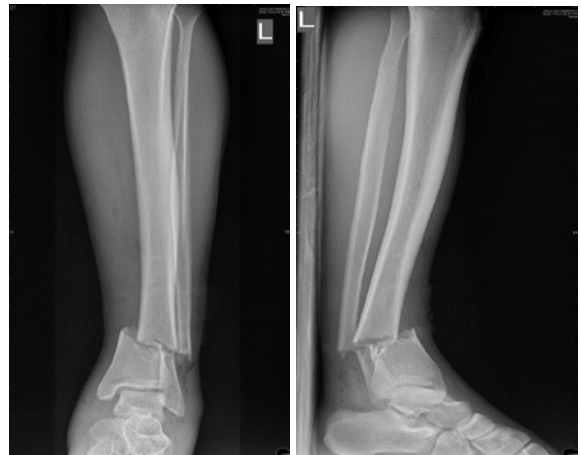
Preoperative Radiograph of Extra articular Distal Tibia Fracture In Anteroposterior And Lateral Views.
